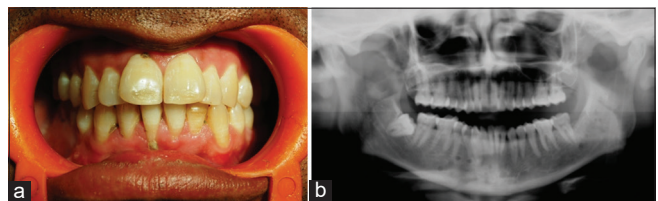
(a and b) Four months follow-up occlusion and radiograph showing fracture segment in proper reduction
